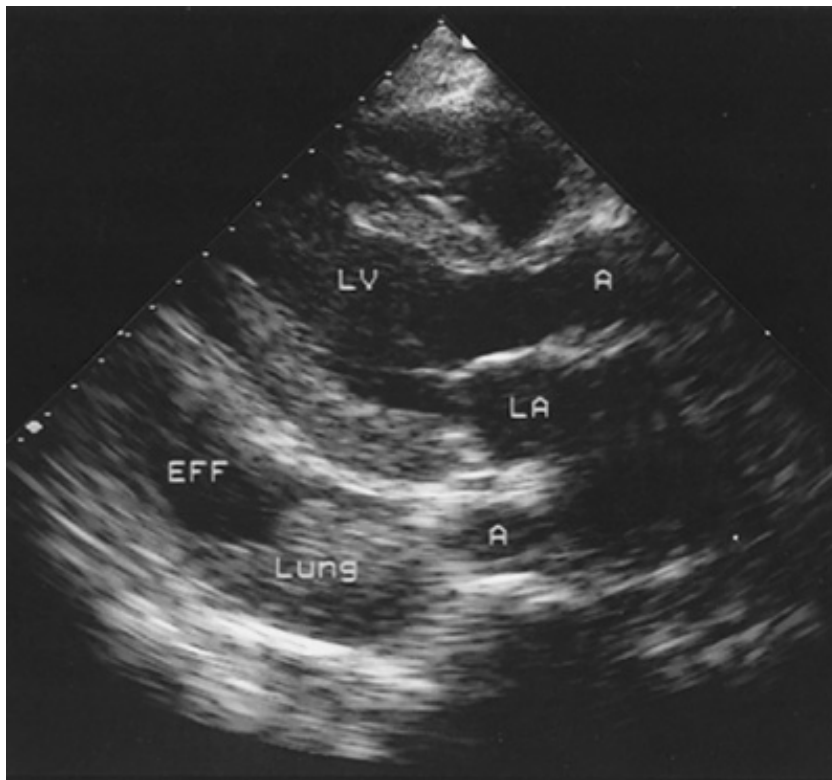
Parasternal long-axis view in a patient with a pleural effusion (EFF) posterior to the heart. Atelectatic lung tissue is present within the effusion. LA = left atrium; LV = left ventricle; A = aorta.
